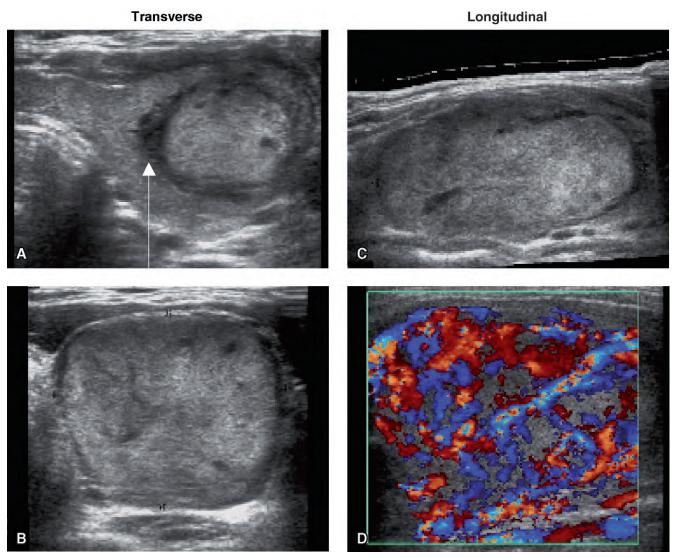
Ultrasound of follicular thyroid carcinoma in the left lobe. A, Transverse, 18 x 32 mm. The arrow indicates the most suspicious area. B, Transverse. C, Longitudinal, sagittal diameter: 23 mm. D, Color Doppler, longitudinal.
